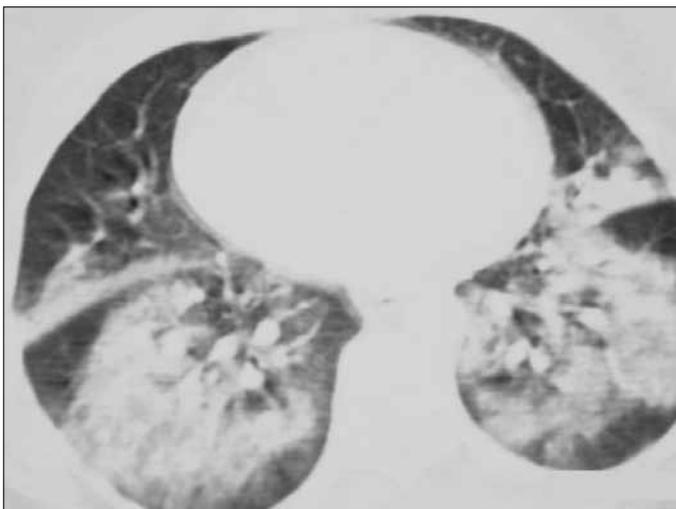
CT scan depicting bilateral patchy reticulonodular and ground-glass infiltrations in the lingula, middle lobe and lower lobes of the lungs
